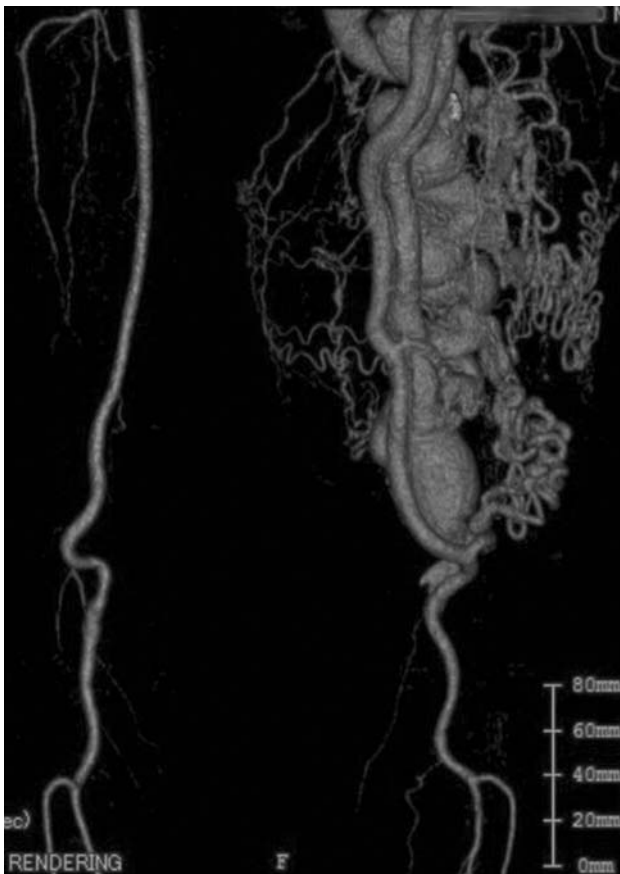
Computed tomography angiography of the lower extremities. Multiple arteriovenous fistulas and varices are observable in the left thigh
